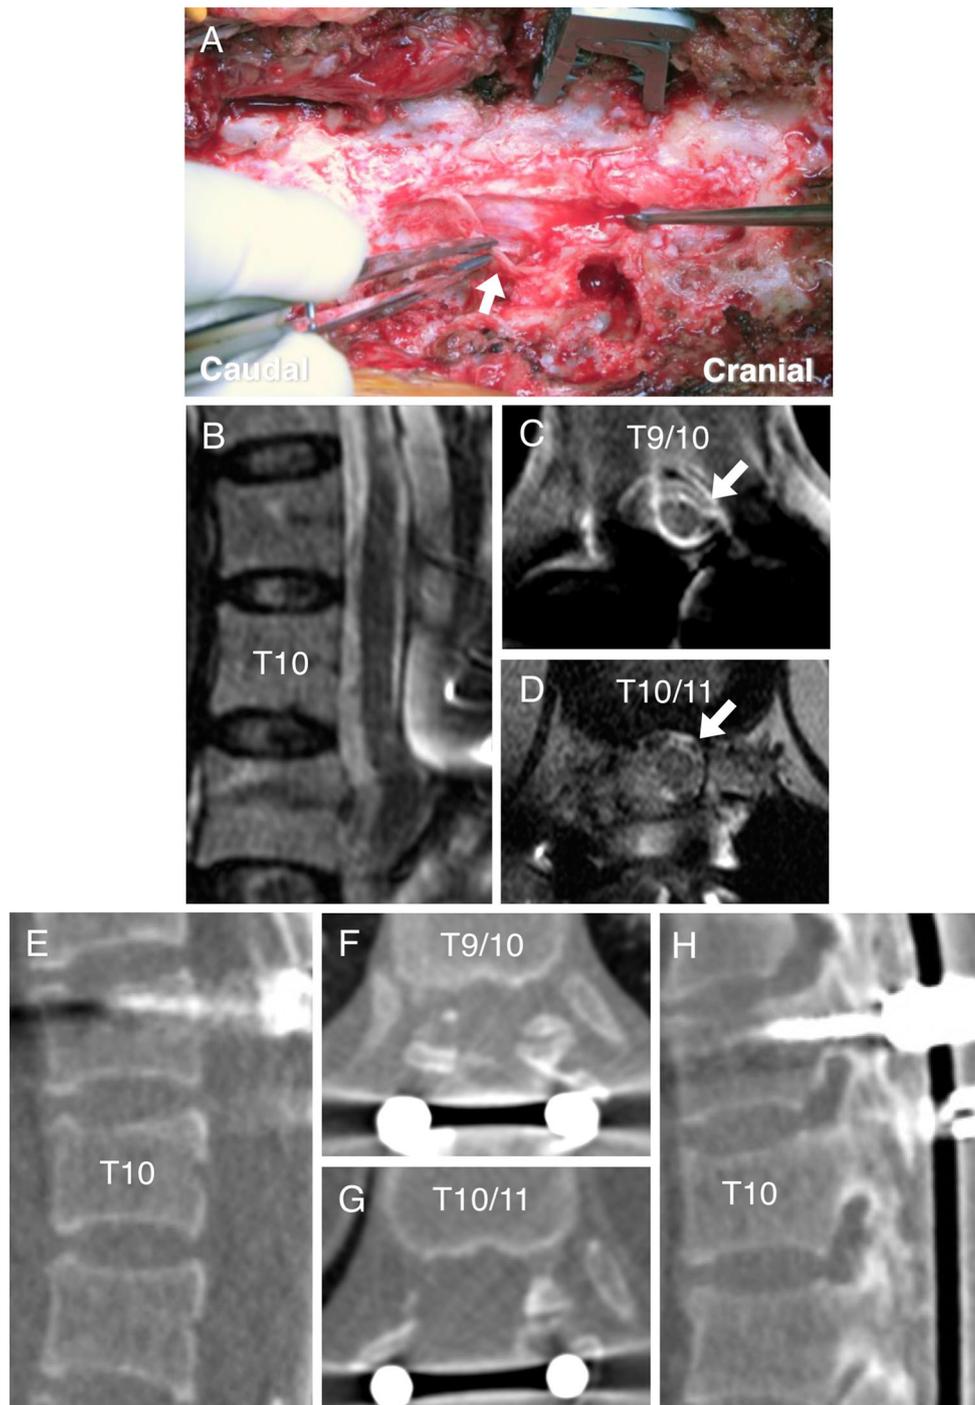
Case 1. Intraoperative photograph and MR images and CT scans obtained after the second operation. The recurrent OLF was strongly adhered to the dura mater, and therefore, the ossified lesion was removed with the dura mater at the T10–11 level (*arrow* in a). Sagittal (b) and axial (c, d) T2-weighted images show that the spinal cord is sufficiently decompressed at the T9–10 and T10–11 levels
